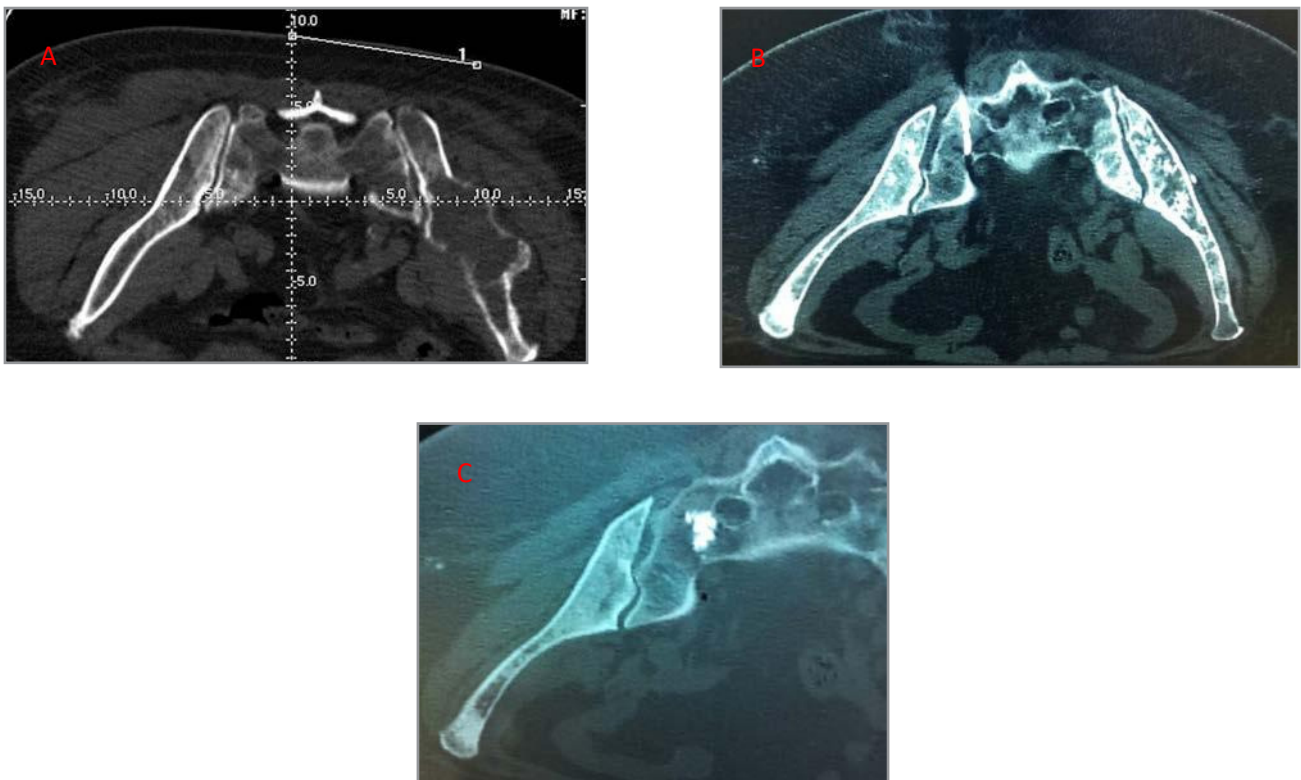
(A) CT image for access needle and RFA probe planning trajectory. (B) Percutaneous sacral access and RFA probe deployment under CT guidance. (C) Injection of high viscosity cement into the sacral metastases ablated.
